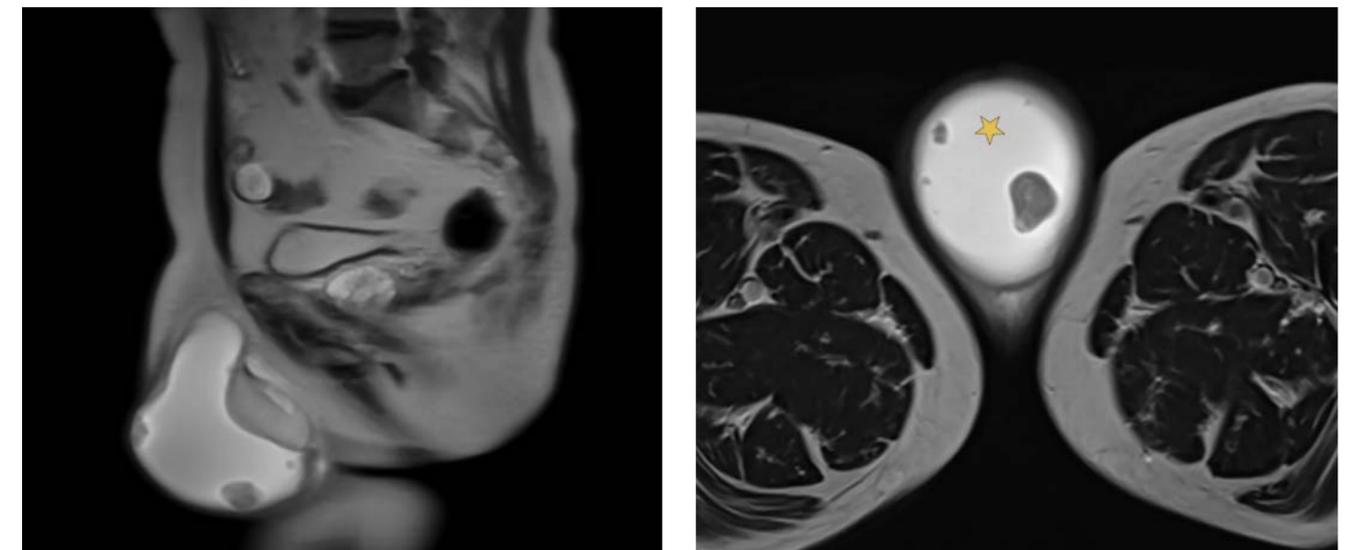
MR images of an encysted hydrocele (indicated by yellow star) with peripheral nodular opacities attached to the wall
